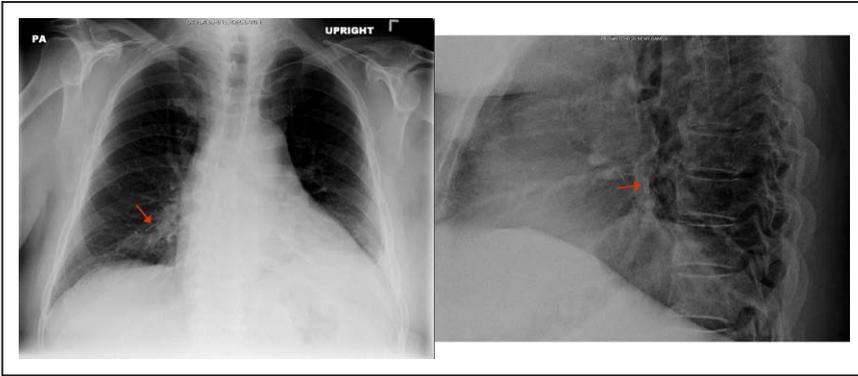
Chest x-ray confirming migration of the sensor into the right lung.
